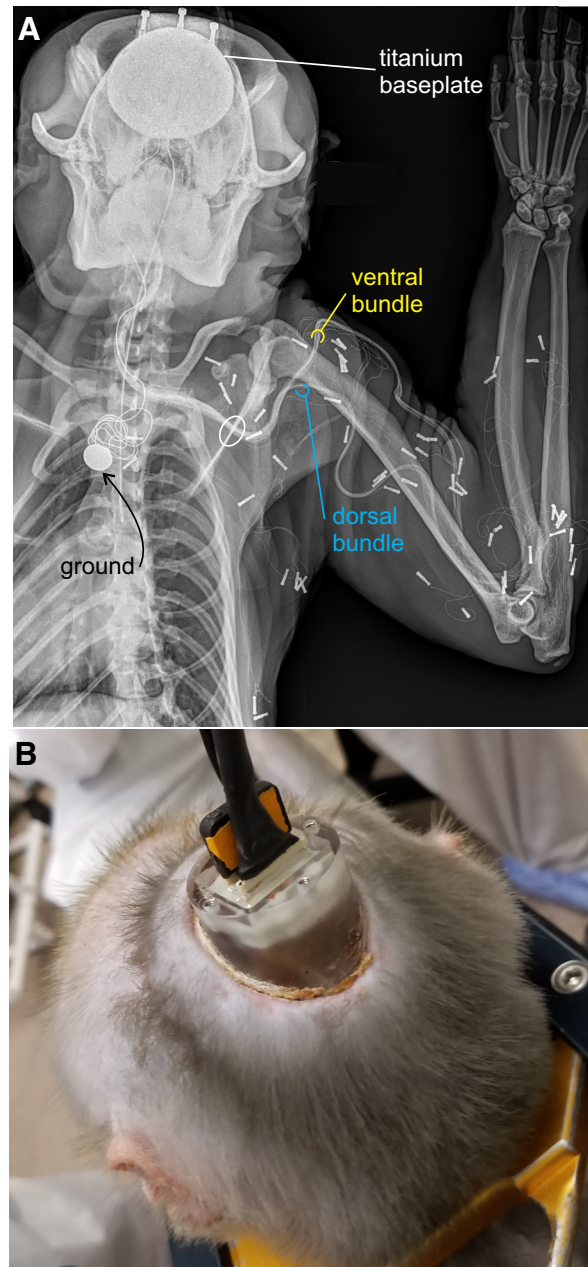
A: radiograph showing implanted system. Titanium baseplate is seen on the skull. Wire bundle passed from chamber on the skull to a midline position where it was routed laterally. Eventually, the main bundle separated into 2 bundles destined for dorsal and ventral muscles of the arm. Individual wires can be seen terminating in anchors implanted in muscles. A disk electrode served as ground and as the return electrode for stimulation. The oval over the spinous process on the scapula indicates a region where skin breakdown eventually occurred. B: photograph of chamber 4 wk after its implantation with cables attached to connector imbedded in chamber. Skin at base of chamber is healthy, with a tight seal between the chamber and skin.
